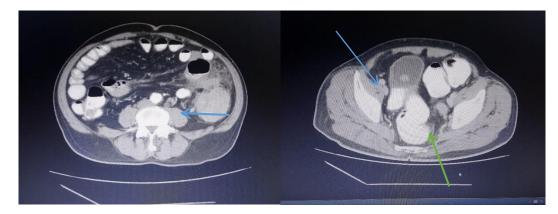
Axial CT images showing Descending Colon mass lesion (blue arrow), Intraluminal Urinary bladder growth (blue arrow) and Left Ureteric mass (orange arrow).
